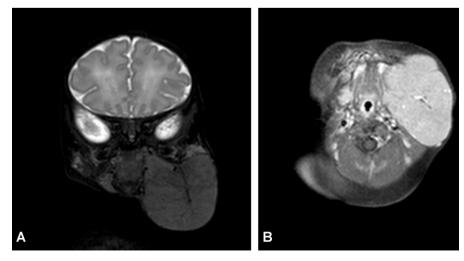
(A) T2-weighted coronal view showing an intermediate signal intensity of the tumor; and (B) axial post-gadolinium T1-weighted images showing a rather high contrast enhancement of the mass.
